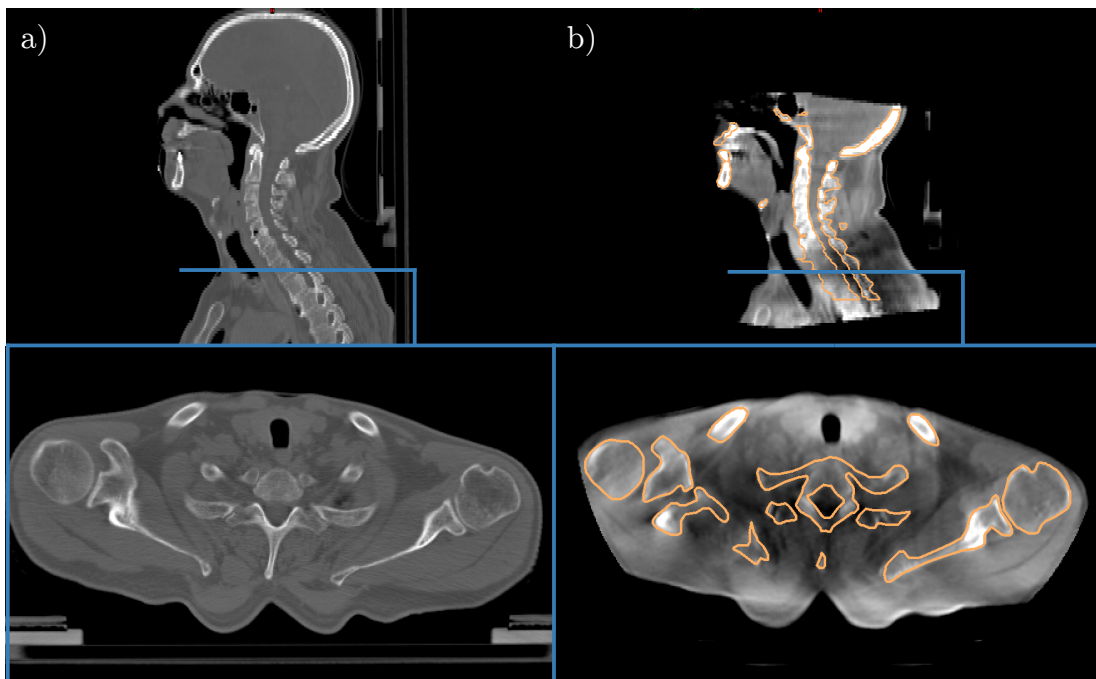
Image quality of CT and MRI slices for patient 1_{CBCT} . a) Sagittal and transversal slice for the CT indicating the measured field-of-view. The blue line indicates the position of the transversal slice. b) Cone beam CT with a limited field of view and semi-automatic skeleton segmentation (orange). The transversal slice shows that the semi-automatic segmentation does not reach the quality of a manual segmentation.
